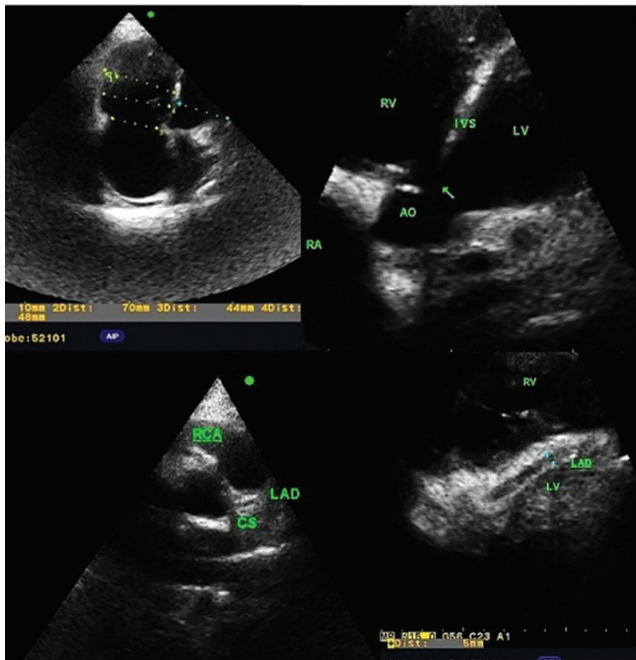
47-year-old male with borderline high blood pressure and dyslipidemia, presenting with atypical chest pain. Left – “RAC” sign caudal to the aortic root in apical view. Computed tomography revealed dual LCx artery with abnormal small caliber branch with a course behind the aorta. No coronary stenoses were identified
